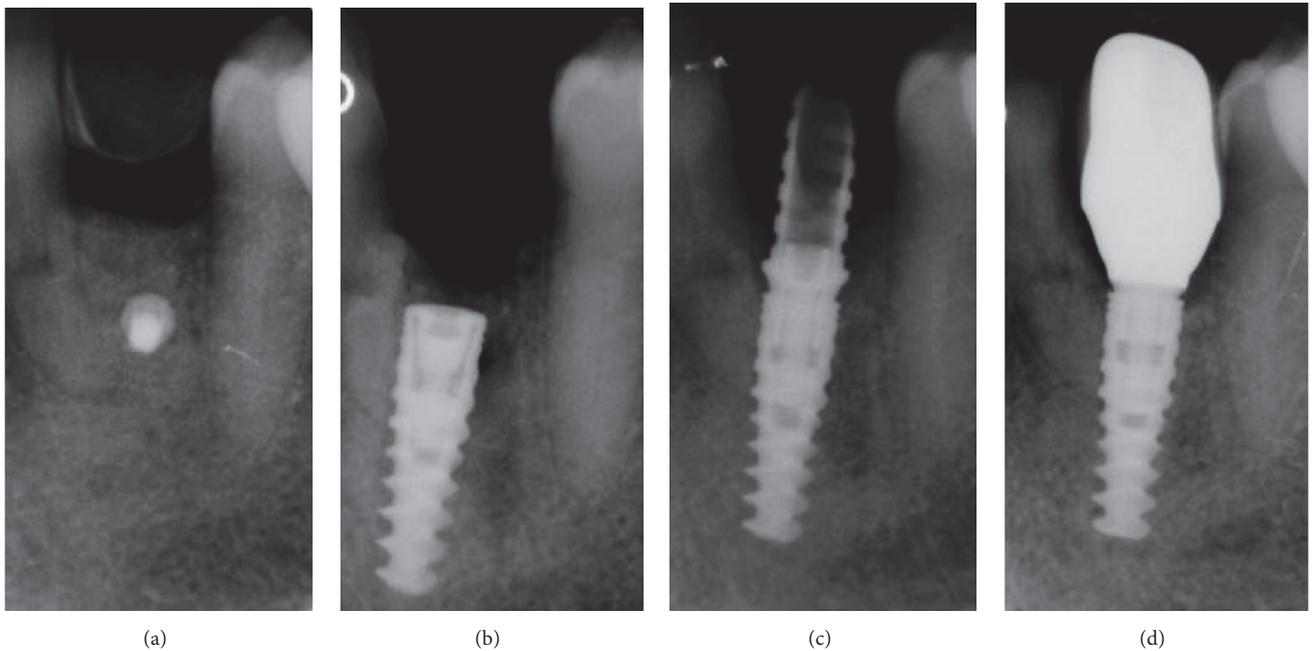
Radiographic history of the case: (a) periapical rx taken immediately after the reconstructive procedure; (b) periapical rx taken immediately after implant placement; (c) the implant during the provisional phase, 4 months after placement of the fixture; (d) final rx control of the definitive crown, 3 years after implant placement.
